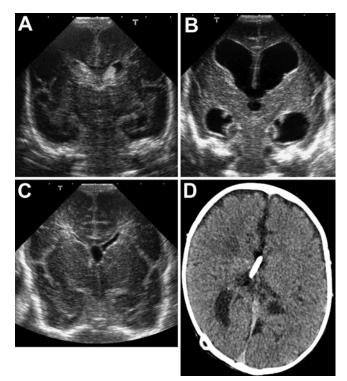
Typical imaging findings for a preterm infant who suffered IVH as a newborn and subsequently developed symptomatic hydrocephalus that required a temporary left frontal subgaleal shunt and eventually a right occipital permanent VP shunt. A-C: Ultrasound images. An IVH Grade II was identified on surveillance cranial ultrasound study within a few days of birth at 26 weeks' EGA (A). After 1 month, ventricular dilation developed and coincided with the onset of physical signs of increased ICP (B). (A study performed after insertion of a VSG shunt showed decompression of the ventricles (C). D: Axial CT scan obtained at 2 years of age. After the neonatal course, this patient required 1 shunt revision for proximal occlusion in 5 years.
